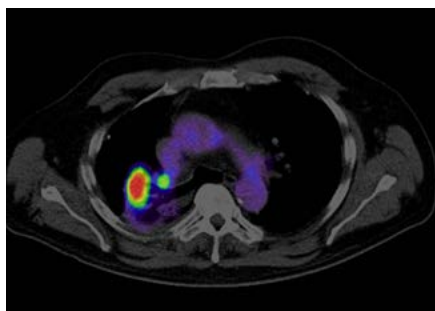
PET/CT image of recurrent tumour in the right lung
